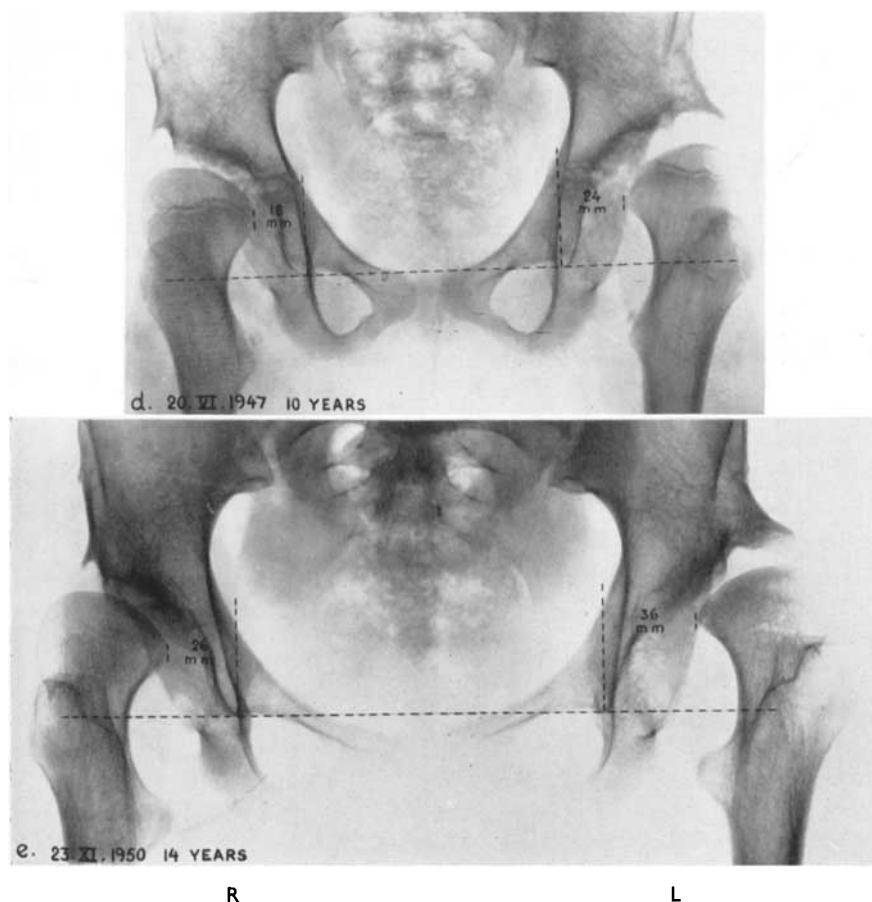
Case No. 3246/38. The horizontal line of the pelvis is seen as a tangent to the inferior convexity of the tear figures. A vertical to the horizontal line is drawn through the tangential point of each tear figure. The distance between the most medial point of the femoral head and the vertical is called CT. The figures show how CT increases at the same time as the femoral head subluxates.
